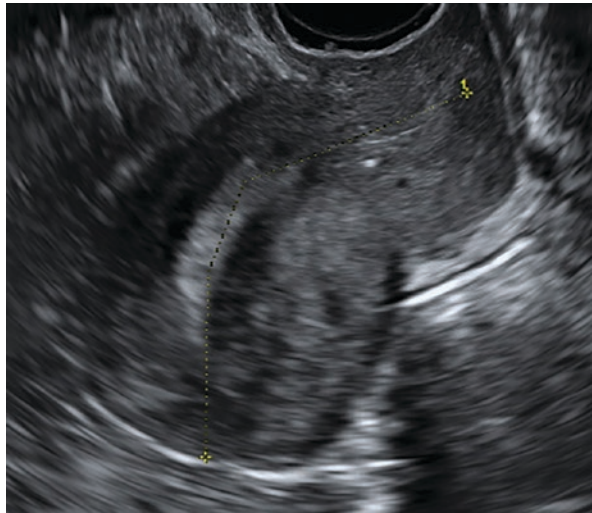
(a, b) Ultrasound images of diffuse adenomyosis of the anterior uterine wall not involving JZ but only the outer myometrium; note the hyperechoic area and the intramyometrial cysts. (b) Power Doppler image showing diffusely spread small vessels
